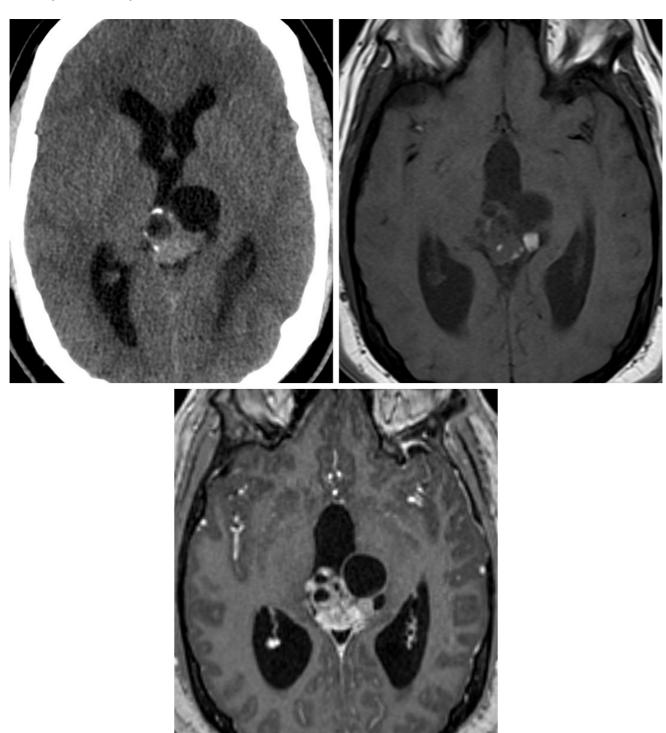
This complex pineal-region teratoma demonstrates areas of solid and cystic change and calcification on a CT image (top left) and areas of hyperintense fat signal intensity on a T1-weighted MR image
